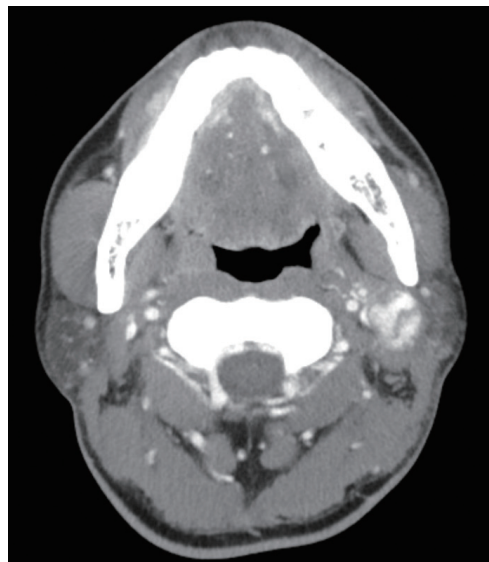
Computed tomography scan (axial section) shows a left proximal occipital artery pseudoaneurysm.
